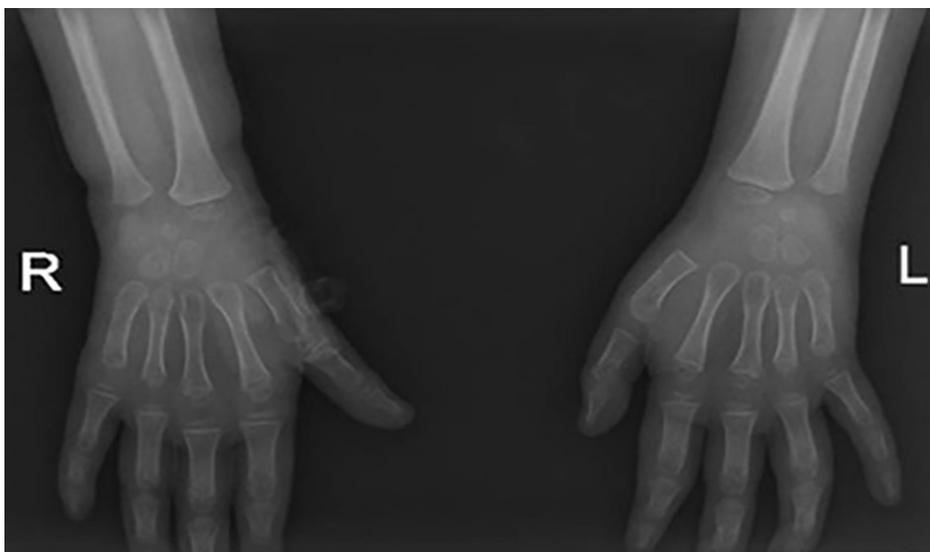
X-Ray Wrist Right and Left (10/01/25) Within normal limits
